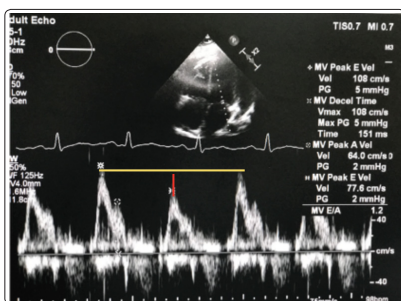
Doppler of mitral inflow shows respiratory variation in mitral inflow velocities (>25%)
